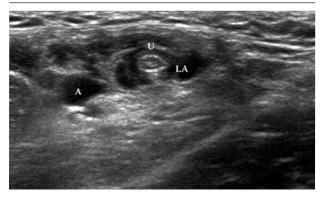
A transverse sonogram showing local anesthetic spread (LA) around the ulnar nerve (U); A = axillary artery.
